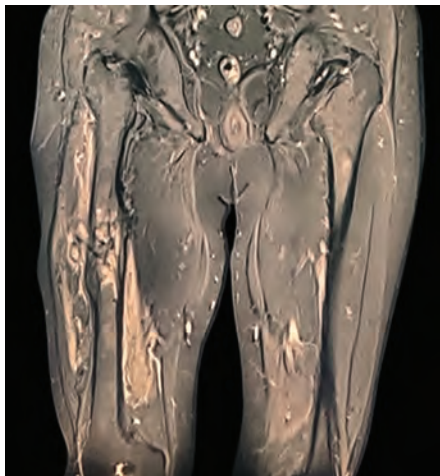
Magnetic resonance imaging (MRI) thigh showing osteomyelitis of metaphyses of the right femur with sinus formation and extension into adjacent muscles
